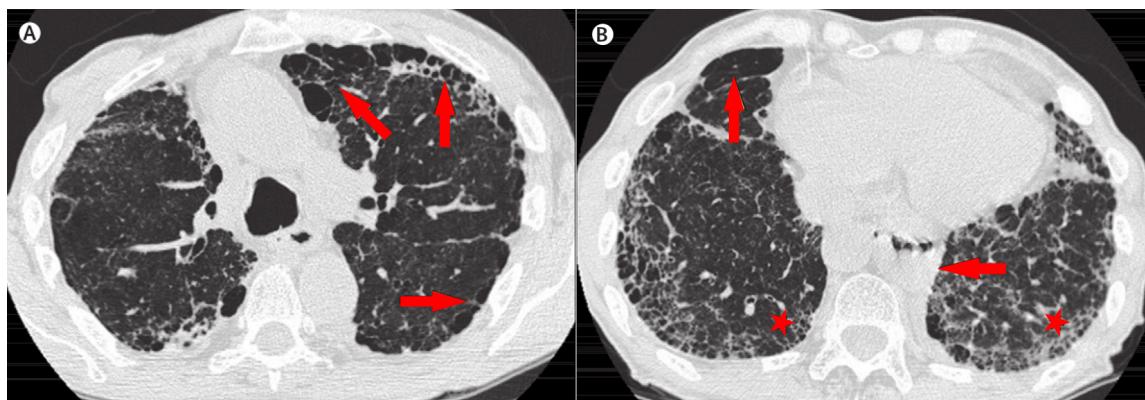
Combined pulmonary fibrosis and emphysema. High-resolution CT shows emphysematous lesions (arrows) in the upper lobes. (A) Emphysema (arrow) and usual interstitial pneumonia-like lesions (stars) in the lower lobes (B). A hiatal hernia is also present (arrowhead). (Reproduced from (King Jr et al., 2011))
